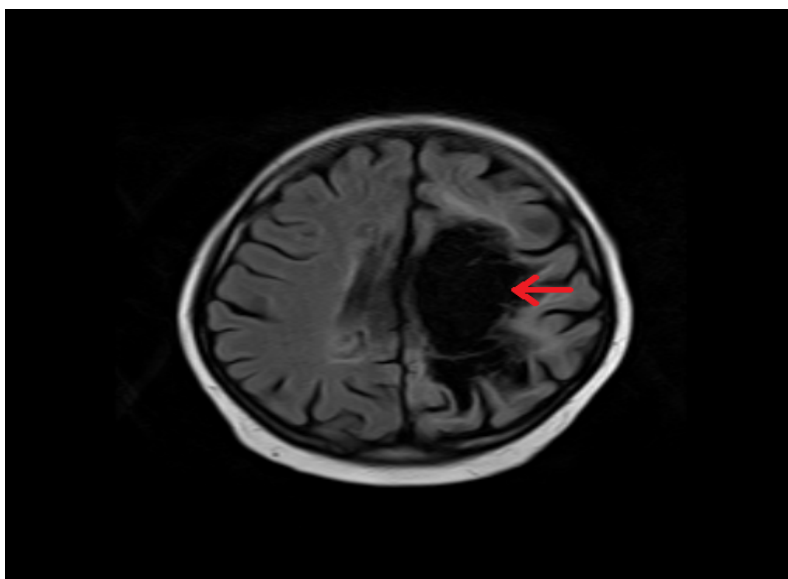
Post chemotherapy MRI
